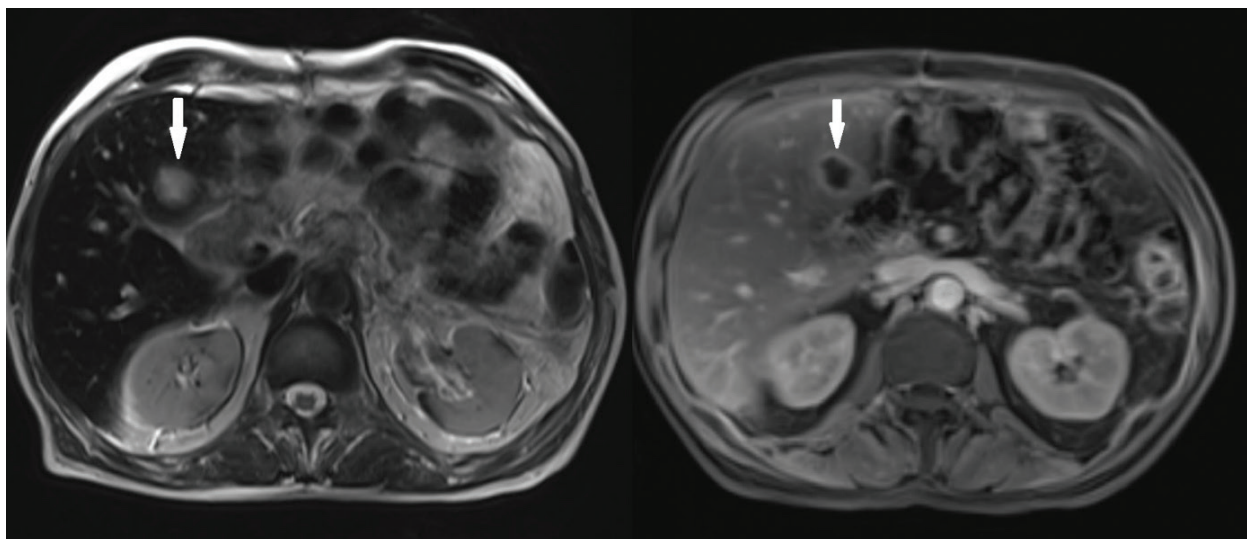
Contrast-enhanced MRI obtained two months after surgery. Axial T2-weighted image (left) shows a thick-walled, cystic, cavitary lesion in hepatic segment 4B (arrow). Axial post-contrast T1-weighted image (right) demonstrates peripheral wall enhancement with a non-enhancing cystic center (arrow). No diffusion restriction was observed (not shown), a finding consistent with hepatic inflammatory pseudotumor
